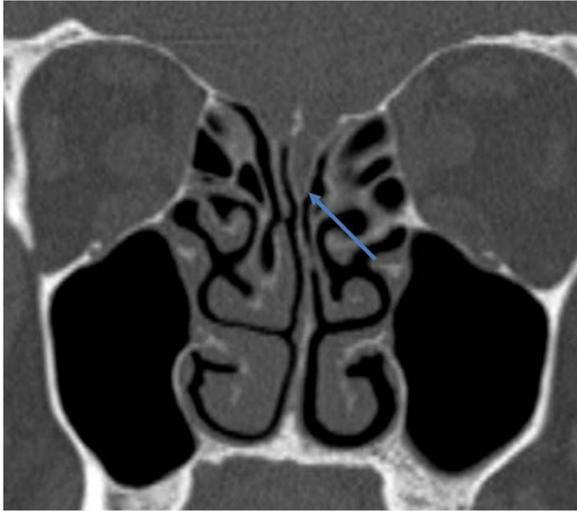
Unenhanced computed tomographic image of the head, coronal plane, three months before the pneumocephalus. Even though the examination was reported as within normal limits, there is an anatomical variant in the cribriform plate with a left olfactory fossa 8 mm deep (Keros type III variant) (arrow).
